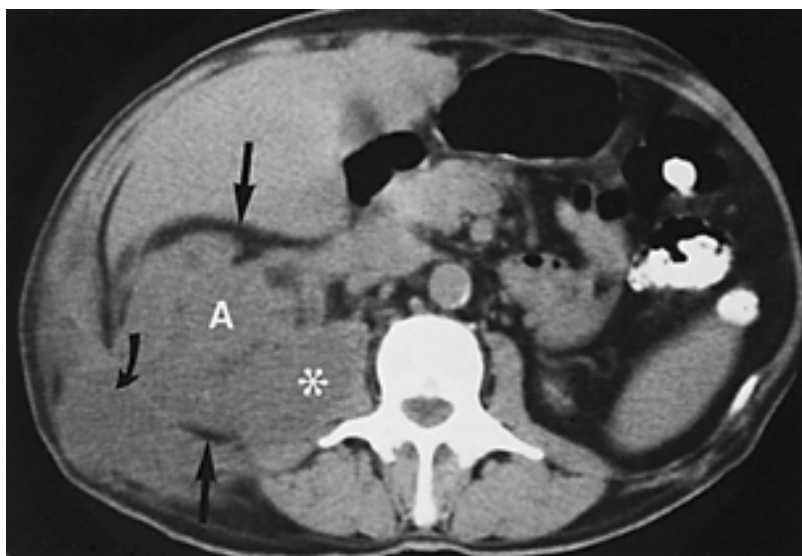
Extensive perinephric abscess. Nonenhanced computed tomography scan through the lower pole of the right kidney (previous left nephrectomy). Extensive abscess (A) distorts and enlarges renal contour, infiltrates perinephric fat (arrows), and also extends into the psoas muscle (asterisk) and the soft tissues of the flank (curved arrow). Also note that normal renal collecting system fat has been obliterated by the process.
